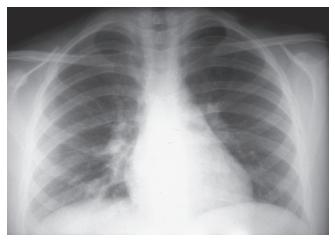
Plain radiograph showing patchy infiltrates in the right lower lobe, typical of *Mycoplasma* or other "atypical" pneumonias. (Courtesy of S. S. Long, St. Christopher's Hospital for Children, Philadelphia, PA.)
